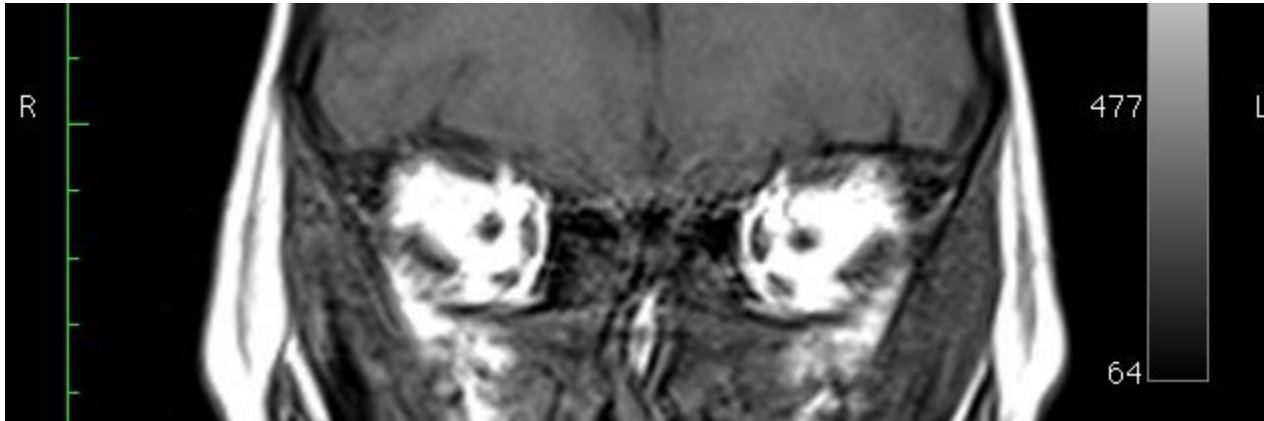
211  $\mu\text{m}$  resolution, 1 mm thick coronal CT scan of the orbits of a 5 year old girl with large "V" esotropia and marked overelevation and underdepression of the right eye in adduction. Note inferior displacement of right LR more than left LR.
